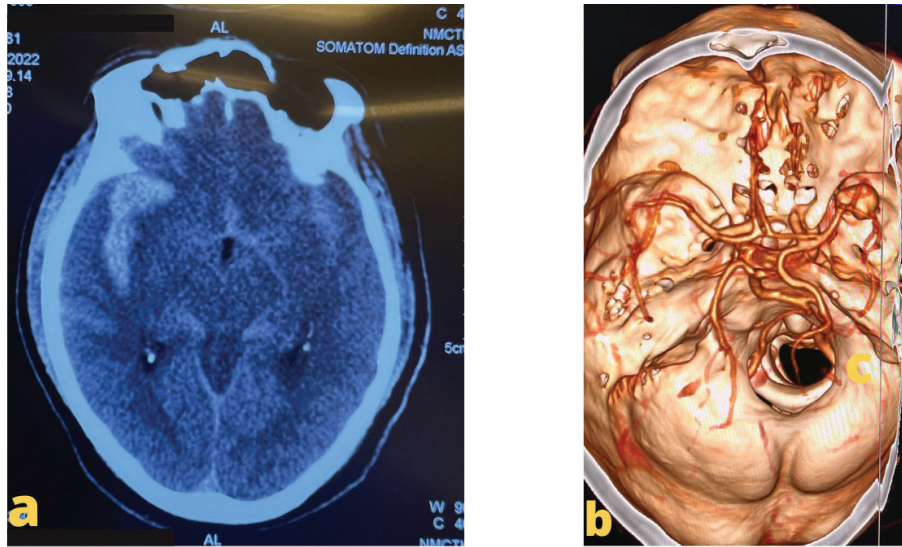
(a) Non-contrast computed tomography of patient with spontaneous subarachnoid hemorrhage showing dense hematoma (blue arrow head) in right sylvian fissure, (b) CT angiography of the same patient showing large MCA bifurcation aneurysm (yellow arrow head)
